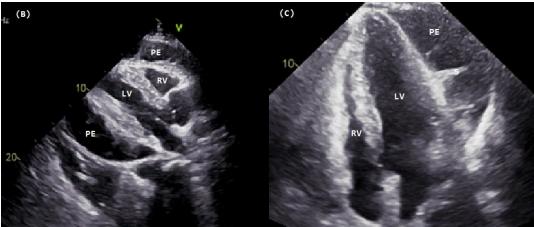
Transthoracic echocardiogram reveals septated, fibrinoid pericardial effusion and right ventricular compression. (A) Parasternal short-axis view at diastolic phase at mid-ventricular level. (B) Parasternal long-axis view at diastolic phase. (C) Apical four-chamber view at diastolic phase.
